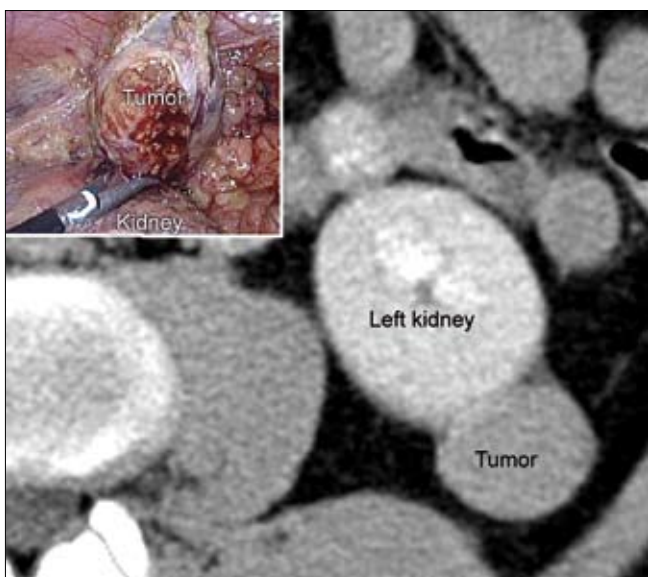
CT shows an extremely exophytic tumor 32 mm in diameter on the lower pole of the left kidney (man, 50-year-old). In the left corner, perioperative figure shows laparoscopic electrodissection of tumor with bipolar dissector.
